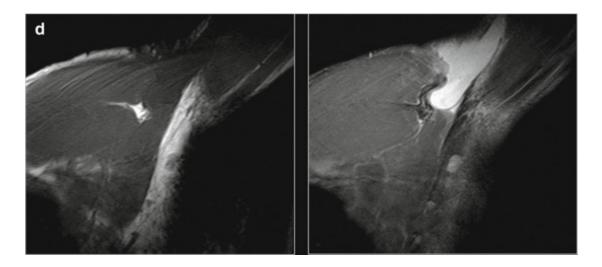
These figures show how MRI is acquired for the pectoralis major muscle in sagittal (a), axial (b), coronal (c), and abduction and external rotation (ABER) (d) planes
